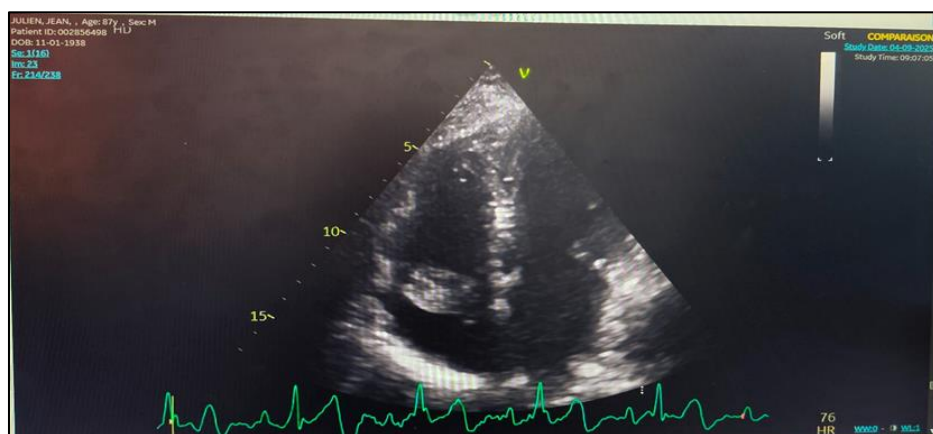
Transthoracic echocardiography revealing a well-circumscribed right atrial intracardiac mass.
